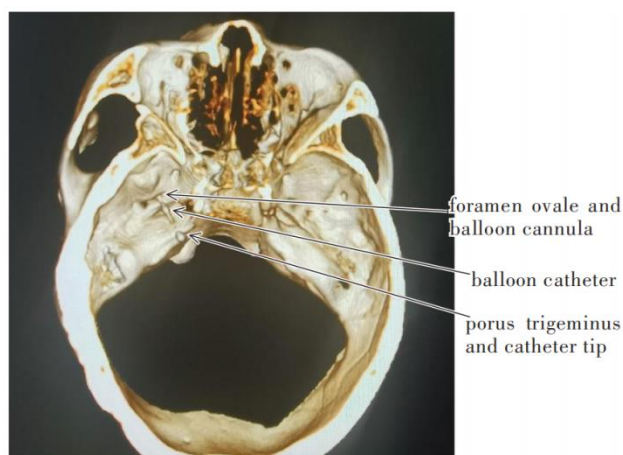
3D CT imaging of the PBC puncture process in a patient with trigeminal neuralgia.
